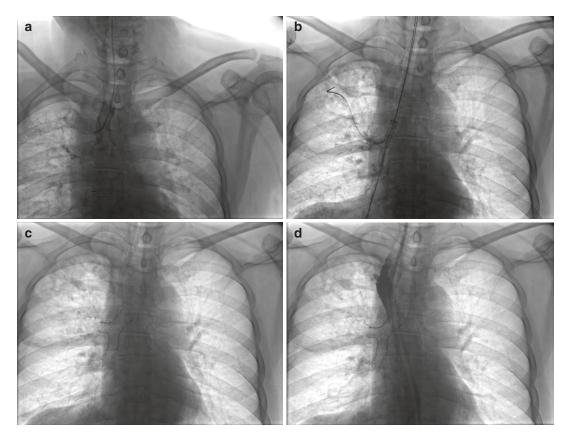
The treatment of one case of thoracostomach-right bronchus fistula (one small Y-stent inserted) (\mathbf{a}) airway radiography showed a thoracostomach-right bronchus fistula (\mathbf{b} - \mathbf{c}) a small Y-stent insertion in the middle bronchus, upper lobar bronchus and right main bronchus (\mathbf{d}) upper gastrointestinal contrastshowed that the fistula had disappeared
